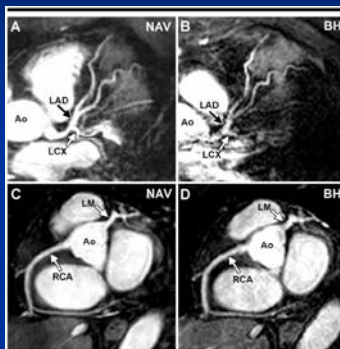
Images in 69-year-old woman. A, B, Multiplanar reformatted MR images (4.5/2.3, 90° flip angle) of LCA system acquired with NAV and BH (sensitivity encoding factor, 2.7) approaches. Note improved delineation of vessel border of LCA system in NAV image. Increased visibility of the LCX and coronary side branches on the NAV image can be appreciated. C, D, Multiplanar reformatted MR images (4.5/2.3, 90° flip angle) of RCA acquired with BH (sensitivity encoding factor, 2.6) and NAV approaches. Note the improved image quality beyond the crux of the RCA on the NAV image. Ao = aorta, LM = left main artery.
